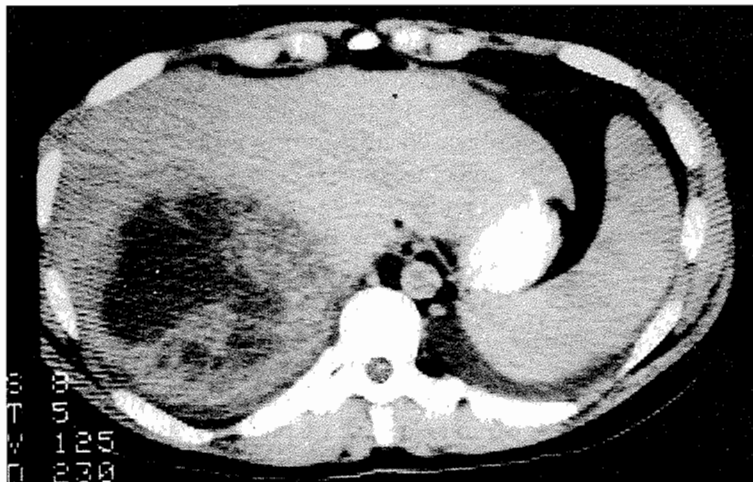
Abdominal CT scan showing a solitary abscess in the right lobe of the liver.
